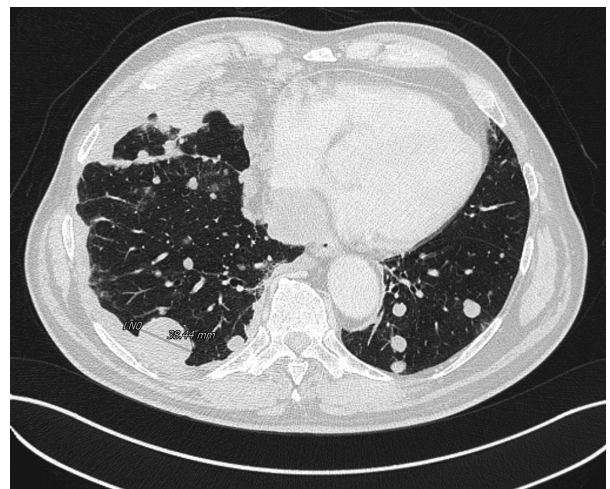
CT scan of the chest in June 2015 showing a continuous progression of the disease
